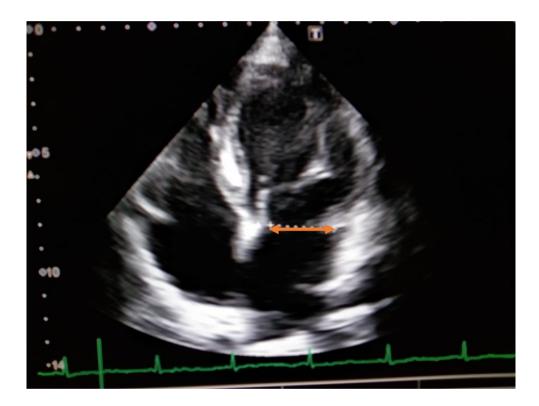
Echocardiographic image measuring an annular diameter of mitral valve in a 4-chamber view from the current study conducted at NICVD, Karachi.
